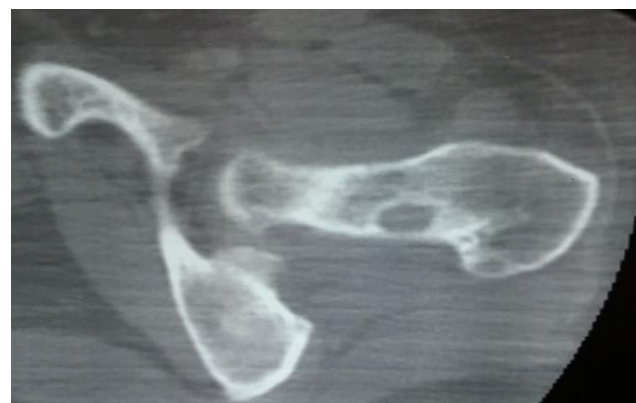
Postoperative CT Scan Showing the Left Bone Lesion
